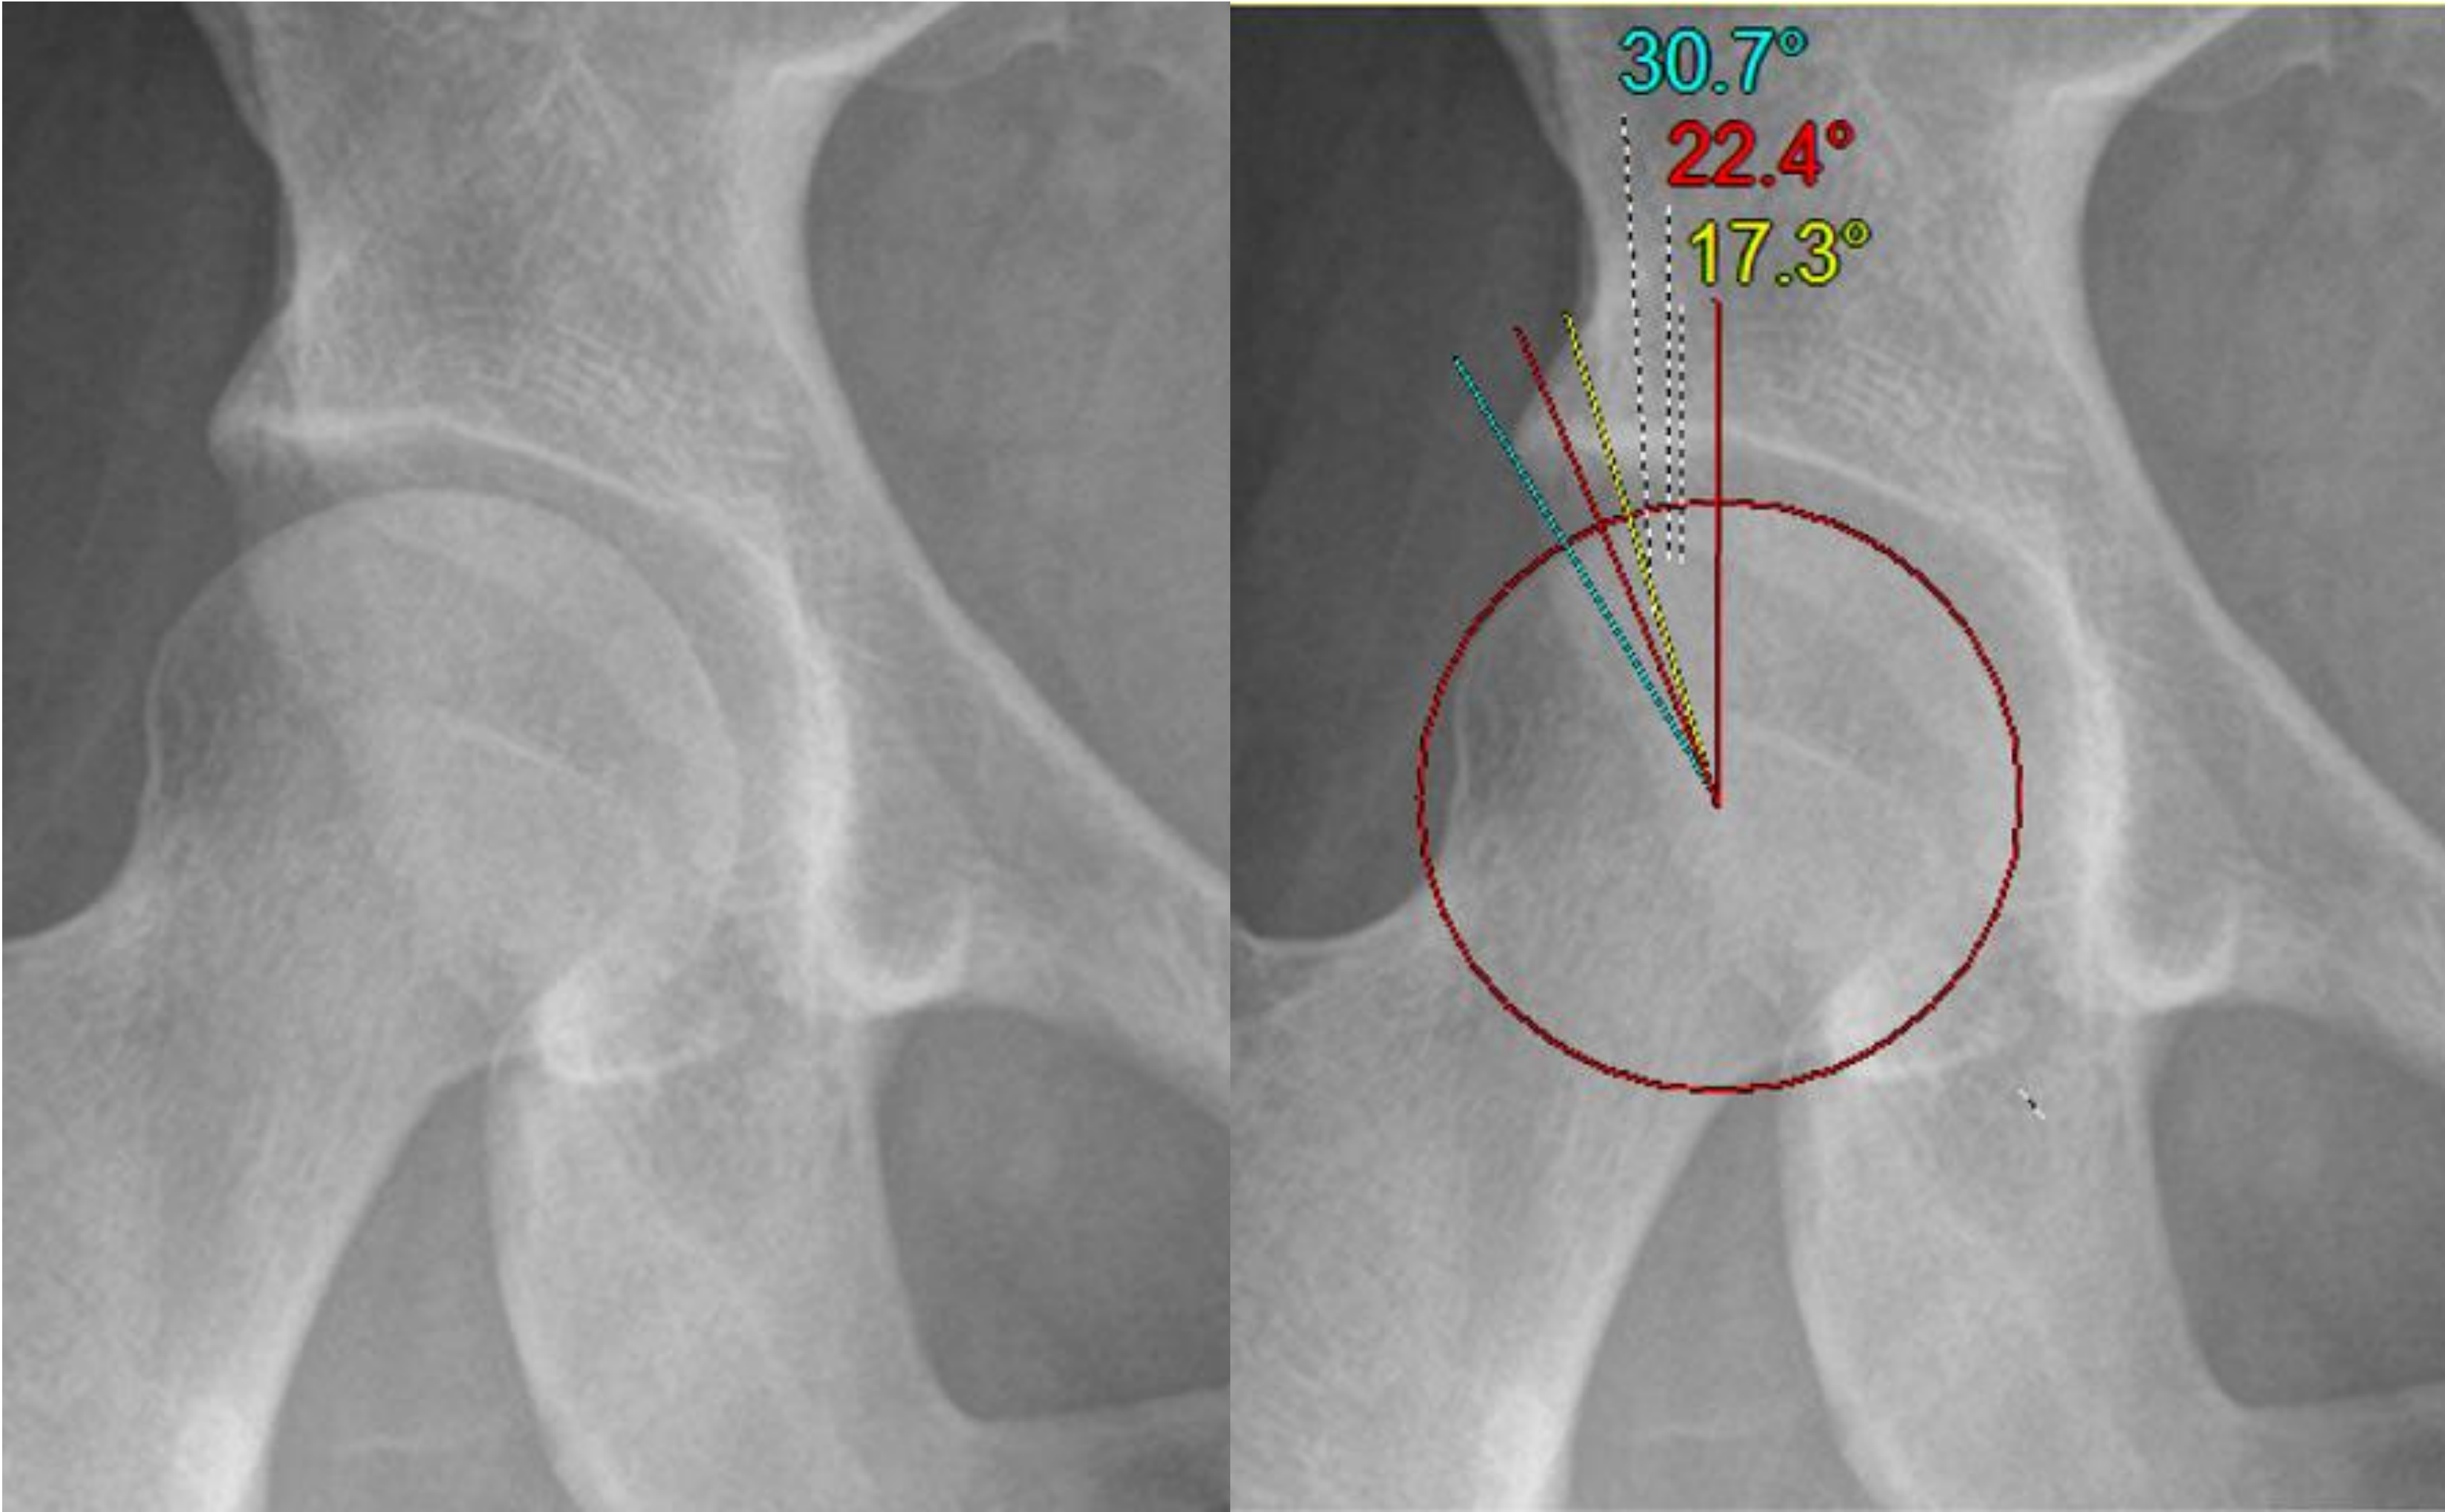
Unmarked AP X-ray image of the right hip on screen left. Demonstration of the LCEA in red (22.4°), WiSA in yellow (17.3°), and WiSP in cyan (30.7°) on screen right.
